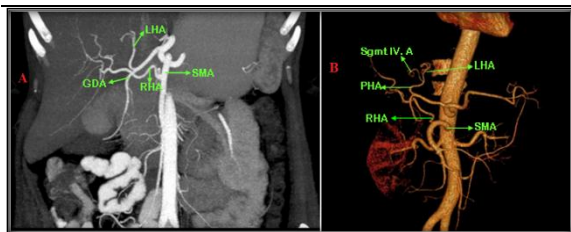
coronal and 3D reconstructed MIP CT angiograms demonstrating Type III with replaced RHA arising from the SMA and the CHA dividing into the LHA and the GDA
